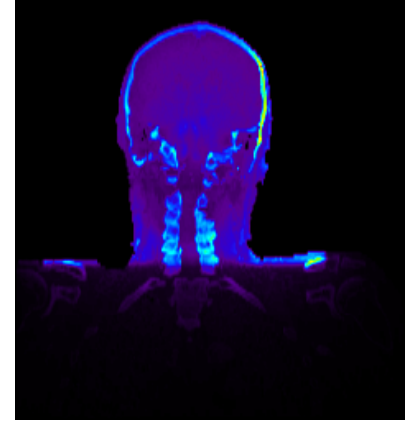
Isocentric slices for Pat. C for a single beam at 0° . The slice positions are marked in the CT-slices shown in (n) - (p).
